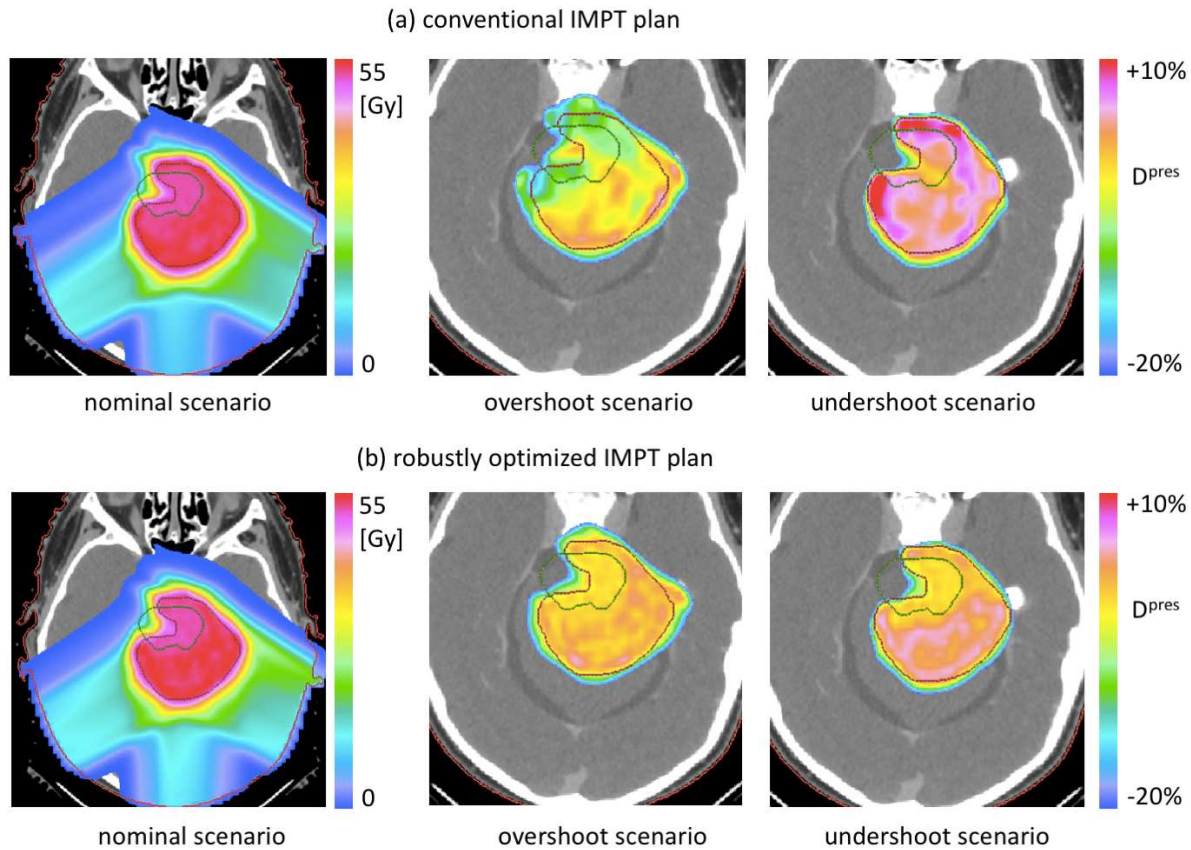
Robustness analysis of the IMPT plans shown in the figure 3. (left) nominal dose distribution; (middle) range overshoot; (left) range undershoot. Range over- and undershoot is modeled by down- and upscaling of the CT Hounsfield numbers by 4.6%.
